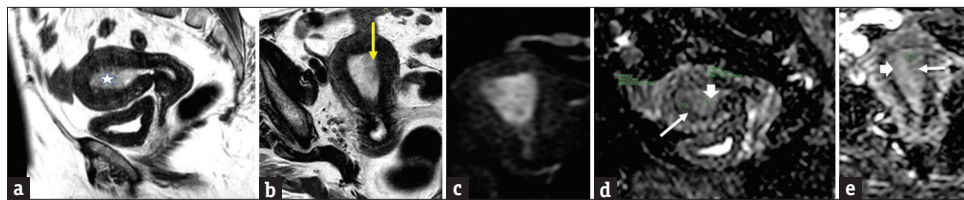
Stage 1A endometrial cancer in a 52-year-old female. (a) Sagittal T2-weighted magnetic resonance image shows distension of the endometrial cavity by an intermediate-signal-intensity tumor (*). (b) Axial oblique T2-weighted magnetic resonance image shows the intermediate signal intensity tumor (yellow arrow) within the hyperintense endometrial cavity along left lateral aspect. The junctional zone is well delineated, with no evidence of invasion. (c) diffusion-weighted image shows restricted diffusion-weighted image and with focal decreased apparent diffusion coefficient (d and e) within this area (0.8–0.9, white arrow) suggesting area of neoplastic changes. ACD within rest of the endometrial cavity is (1.3–1.4 arrow head)
